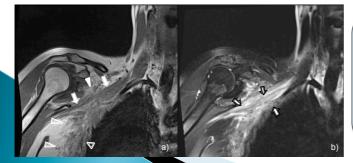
MRI brachial plexus: Coronal oblique (a) tSE T1weighted and (b) fat suppressed T2-weighted MR images of the right thoracic outlet reveal extensive tumour infiltration of the breast (void arrowheads) spreading into the soft-tissue of the infraclavicular and retropectoralis minor area along the course of brachial plexus nerves (arrows). The cords appear diffusely swollen and hyperintense on T2w images as a result of intraneural involvement by tumor tissue. Some regional tymphadenopathies (white arrowheads) are also seen.
